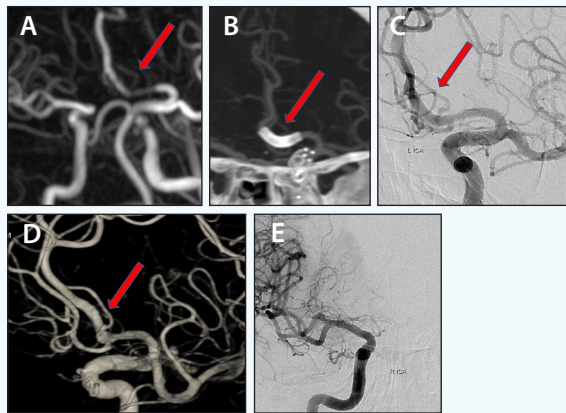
One-month contrast-enhanced MRA (A), 6-month CTA (B), and 1-year DSA (C-E) showing occlusion of the aneurysm, while patency of the right A2 and the subcallosal artery (arrows) is preserved. There was minimal enlargement of the subcallosal artery at its origin within the aneurysm sac due to flow remodeling (arrows; C, D). Note that the right A1 was not present despite the flow demand (E).
